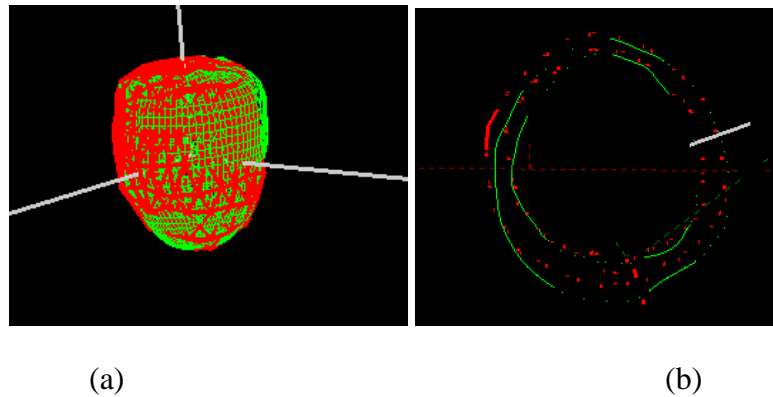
Geodesic models of DEMR and CTA after PCA registration for Patient 1 in 3D (a) and in a short axis view (b).
